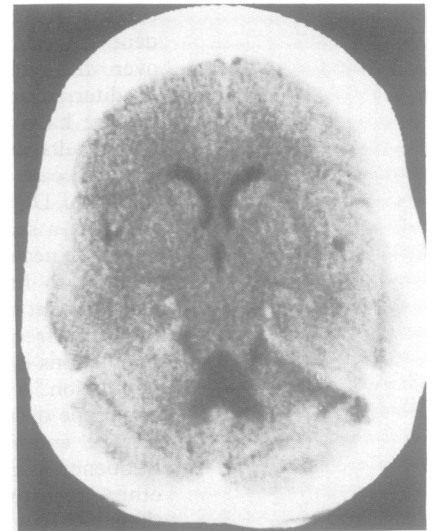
CT scan showing atrophy of the left cerebellar hemisphere, corresponding closely with abnormally perfused area on SPECT.
